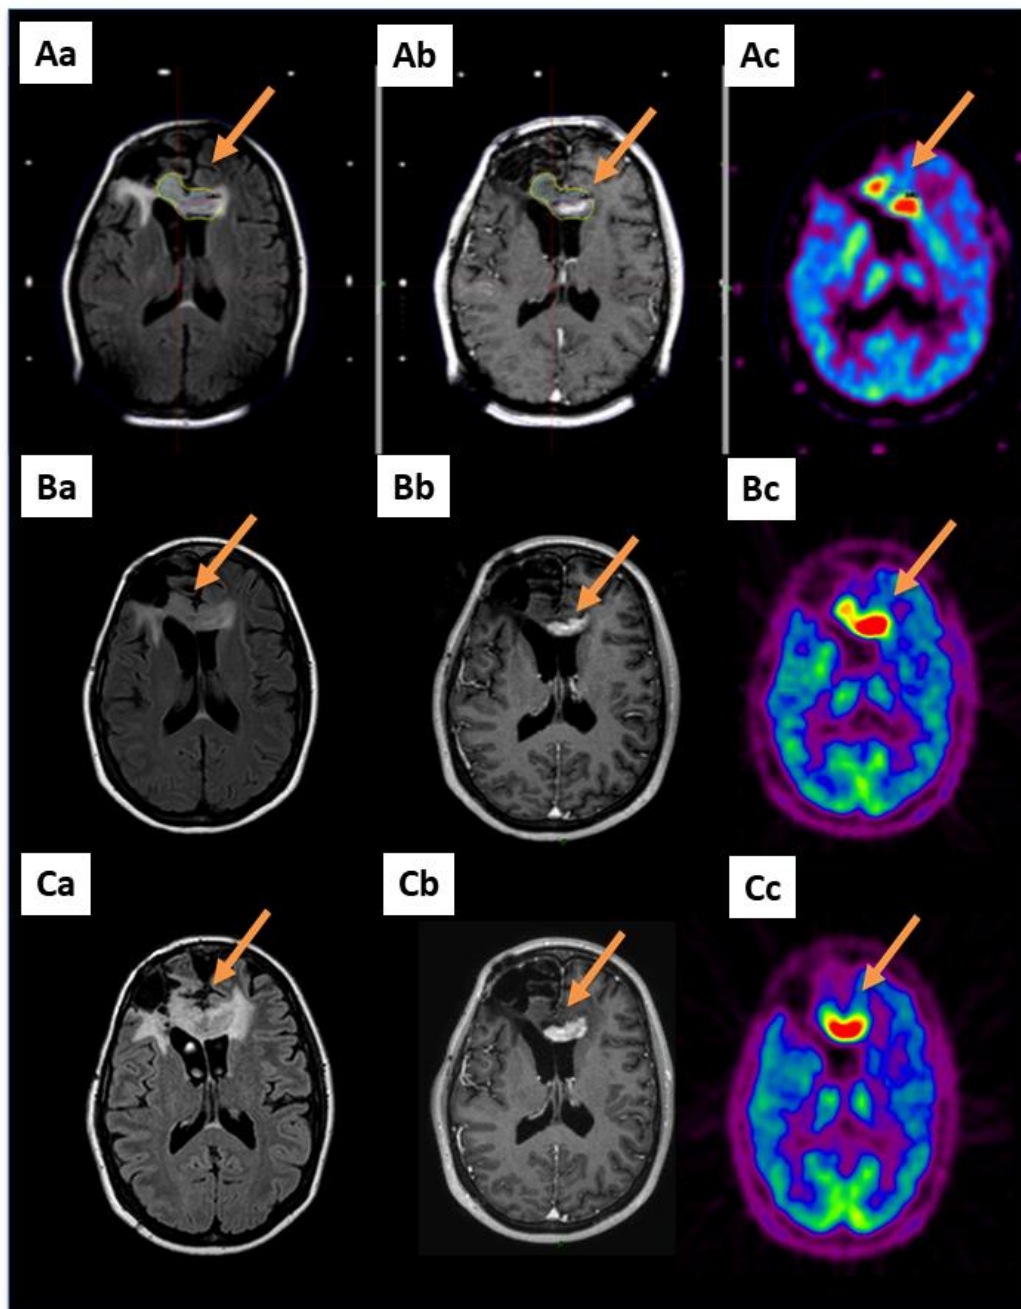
A 36-year-old patient with a glioblastoma (patient 6 in Table S1) already treated by the Stupp protocol after a cerebral biopsy presented with a radiological progression located in the corpus callosum 2 years after her diagnosis (arrows). A GKRS treatment, 15 Gy on a volume of 9716 mm³ including the MET-PET target, was performed. Aa: MRI reformatted axial FLAIR; Ab: reformatted axial T1-weighted with contrast and Ac: MET-PET study performed on the day of the GKRS treatment; B and C show the same sequences 3 and 6 months after GKRS, respectively. Three months after GKRS, MET-PET (Bc) indicated suspected local failure. Six months after the GKRS treatment, all exams confirmed the progression (C: same sequences).
